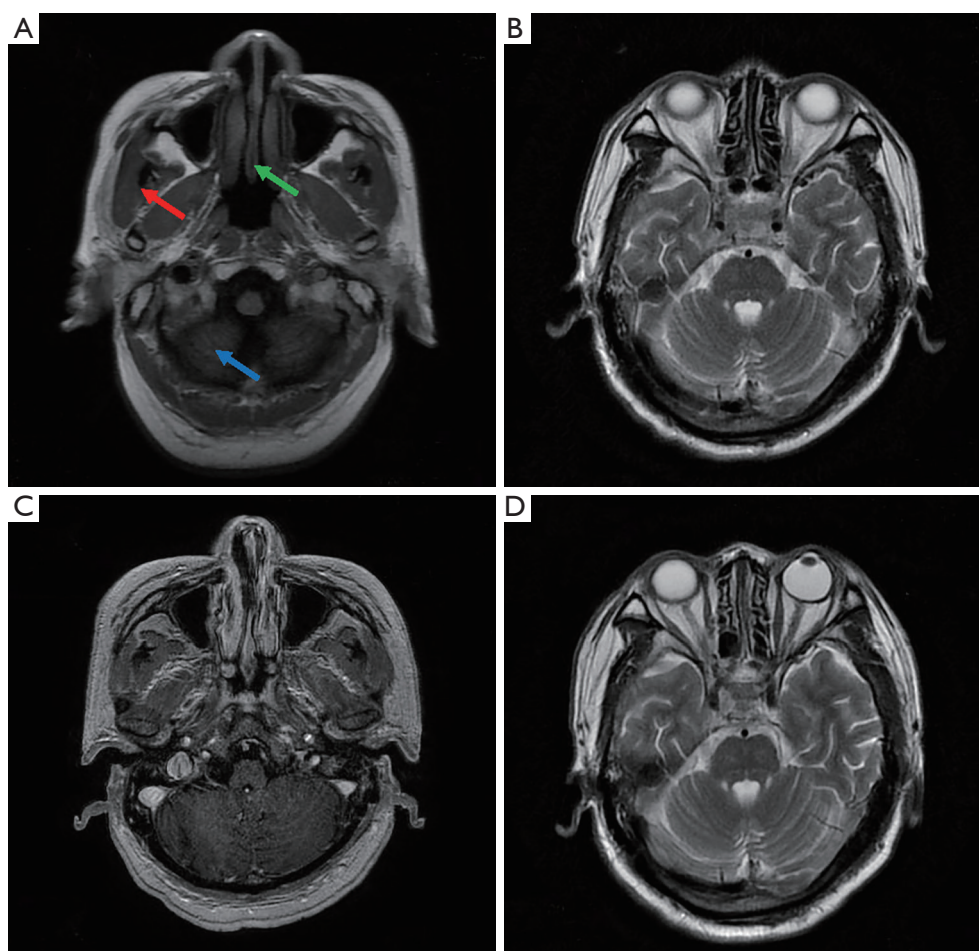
T2WI and T2-FLAIR sequences showed a few patchy with high signal shadows in the parietal lobe of both frontal lobes, while those on T1WI (B,D) and FLAIR (A,C) sequences were normal. No abnormal enhanced patchy was found with enhanced brain parenchyma (red arrow). The shape, size and signal of the ventricular system are normal. The midline structure of the brain is in the middle (green arrow). The shape, size and signal of cistern and sulcus were normal (blue arrow). The structure of saddle area is normal. There were no pathological changes in the structure and signal of skull base. Progression of changes seen between January 2021 (A,B) and February 2021 (C,D) while on carelizumab. In addition, both magnetic resonance imaging showed no pathological changes in the skull base structure, and the patient had no brain metastasis of the tumor. T2WI, T2 weighted image; T2-FLAIR, T2-fluid-attenuated inversion recovery.
